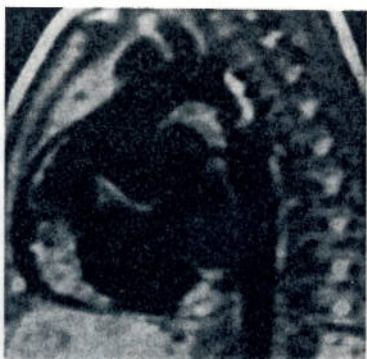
One year old girl with coarctation of the aorta. Sagittal oblique 3-mm spin-echo MRI (LAO equivalent) demonstrates the thoracic aorta in its entirety and depicts well the hypoplastic arch between the left carotid and left subclavian artery, aortic isthmus, and coarctation.
